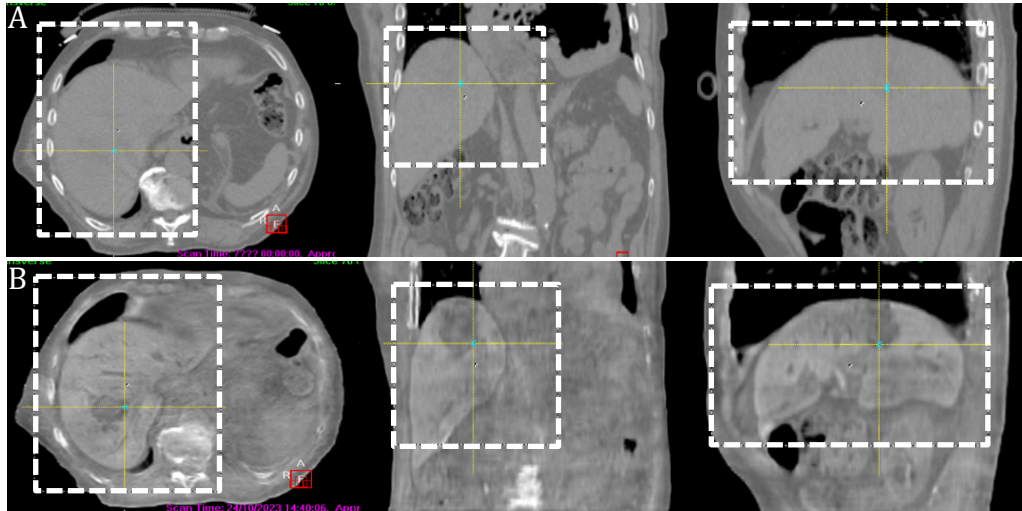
Example of image registration clipbox positioned on a reference (A) CT and (B) sCT images for a liver patient in XVI (Elekta). The axial slice in (left), coronal (middle), and sagittal (right).
